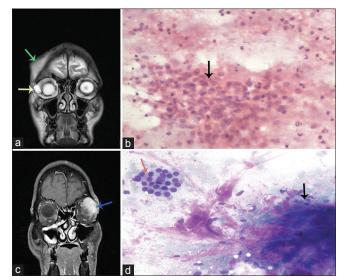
(a) MRI T2 Coronal image of tubercular lesion showing a large collection in the subgaleal region of right frontal bone (green arrow) extending inferiorly to the orbit (yellow arrow) with uniformly hyperintense signal in the center and hypointense rim. (b) Smear showing epithelioid granuloma (black arrow) in a case of orbital tuberculosis (Pap, ×400). (c) MRI T2 C+ Coronal image of pleomorphic adenoma showing well-defined oval shaped homogenously enhancing extraconal lesion along the superolateral aspect of left orbit (blue arrow). (d) Smear of pleomorphic adenoma showing clustered benign epithelial cells (orange arrow) and few spindle cells enmeshed in a fine fibrillary magenta colored ground substance (black arrow) (Giemsa, ×400).
